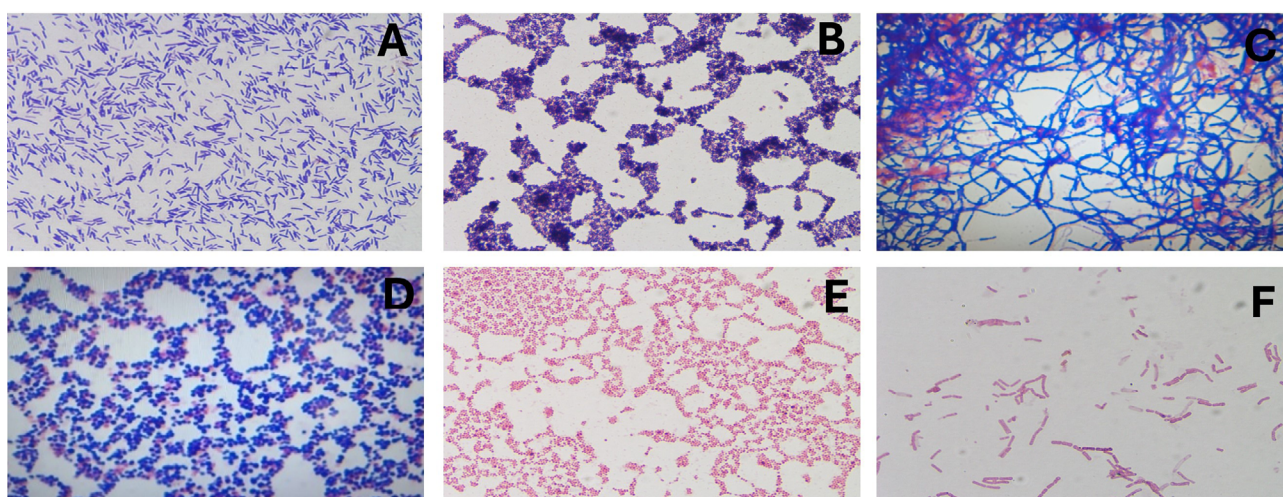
Microbiological findings. (A) Gram-positive bacilli; (B) Gram-positive staphylococci; (C) At the root apex, Gram-positive microbiota, streptobacilli, and streptococci were identified; (D) In the sample obtained by aspiration of periapical exudate under aerobic conditions, (E) Gram-negative staphylococci and (F) Gram-negative streptobacilli.
